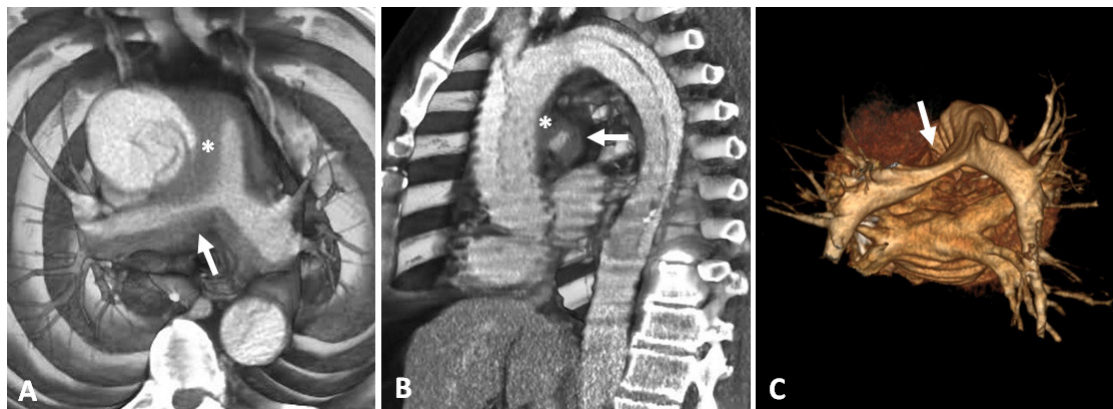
Three-dimensional reconstructions of a 16-row multi-detector computed tomography angiography, show acute aortic dissection (Stanford type A) associated with secondary hematoma (asterisk), involving the pulmonary artery trunk and its main branches. It is more evident on the right, determining luminal reduction of its proximal portion (white arrow).
